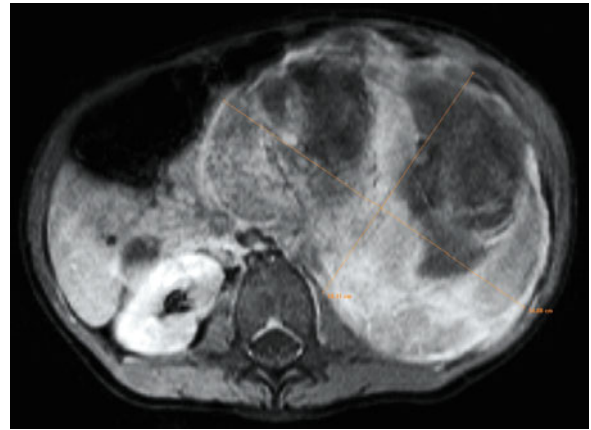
MRI at the time of diagnosis in a 9-year-old girl with CCSK. Tumor volume at the time of diagnosis: 1,370 mL with no regression after 4 weeks of preoperative chemotherapy according to the SIOP Wilms tumor protocol with vincristine and actinomycin-D
